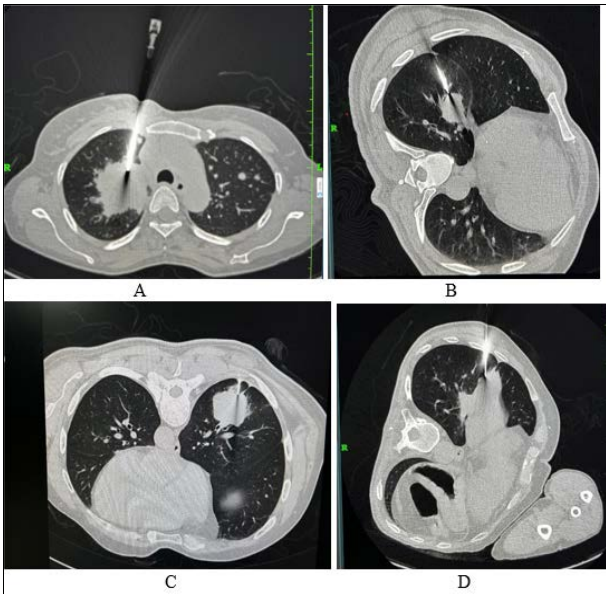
a, b, c, d: Showing CT guided biopsy planning for different lung primary lesions in supine, prone and lateral oblique positions.
